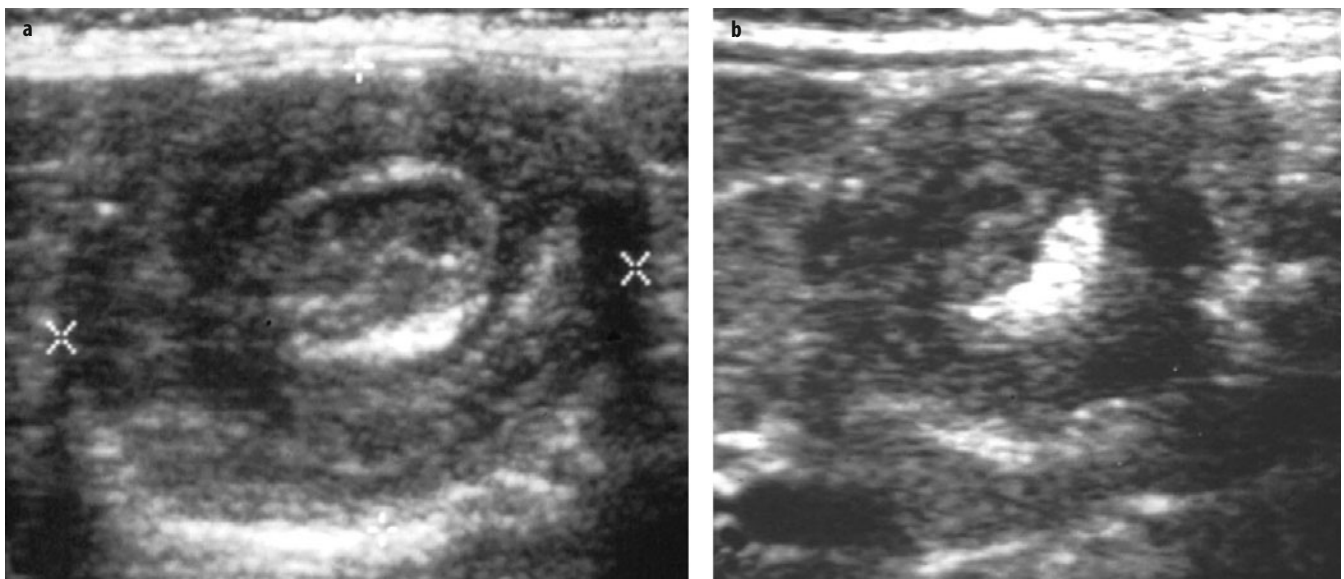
a, b. Ultrasound (US) images of ileocolic intussusceptions in two children. In both, intussusceptions are seen in the transverse view and have a target appearance. The specific finding that characterizes this target appearance as an intussusception is the curvilinear hyper-echoic mesenteric fat seen in both cases between the layers of the intussusception
